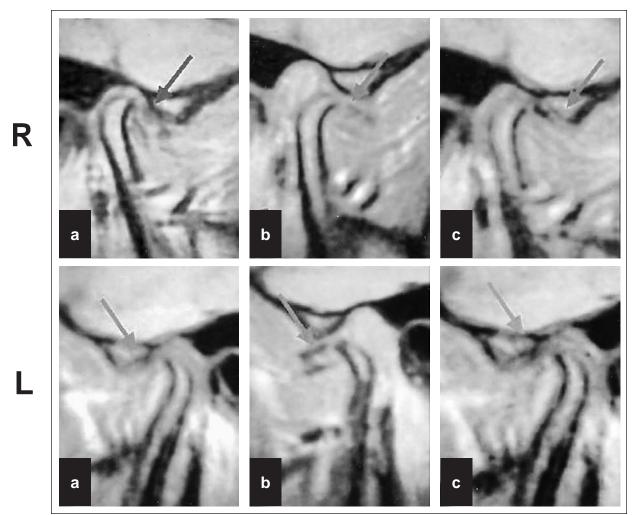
Magnetic resonance imaging (MRI): an anterior dislocation of the disc on both sides when the patient occluded into maximum intercuspal relationships (Figure 3a) and during mouth opening (Figure 3b) is evident. The position obtained with the appliance was then checked by MRI (Figure 3c).
